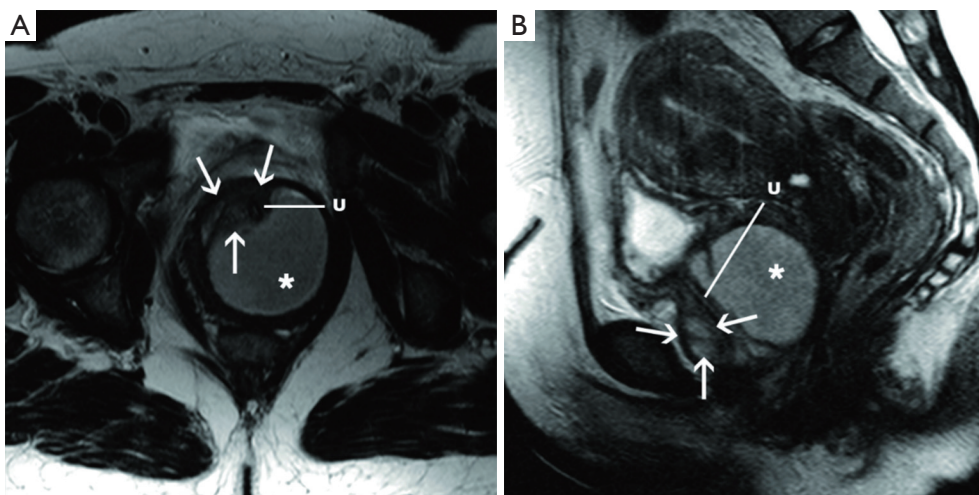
MRI at presentation. Axial (A) and sagittal (B) fast spin-echo T2-weighted sequence show a large fluid filled urethral diverticulum (*) displacing the urethra (U) anteriorly. Heterogeneous low T2 signal in the anterior portion (arrows).
